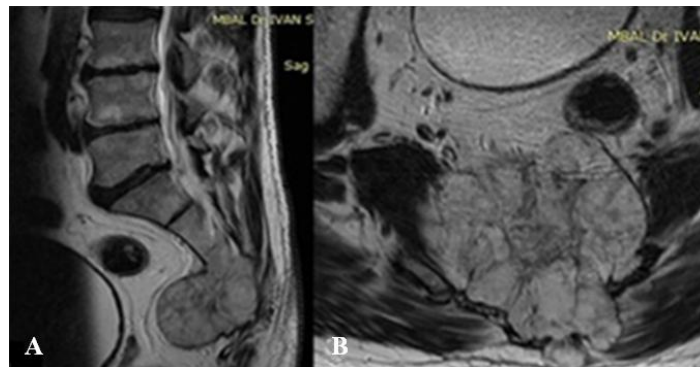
MRI images of chondrosarcoma at S₃-S₅ level:
